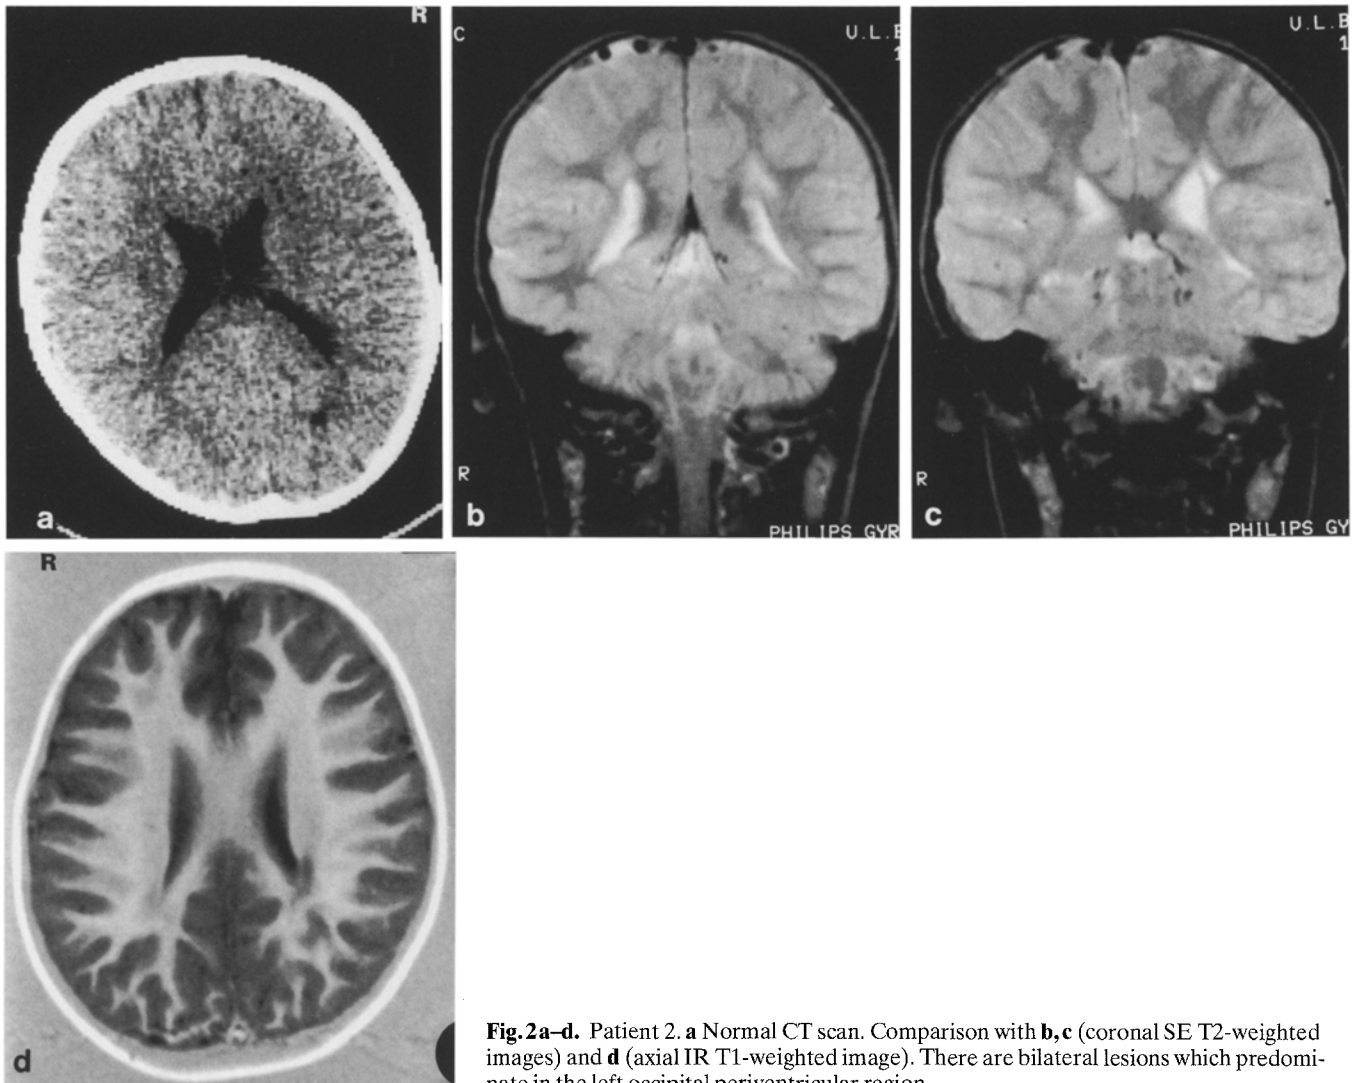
Patient 2. a Normal CT scan. Comparison with b,c (coronal SE T2-weighted images) and d (axial IR T1-weighted image). There are bilateral lesions which predominate in the left occipital periventricular region
